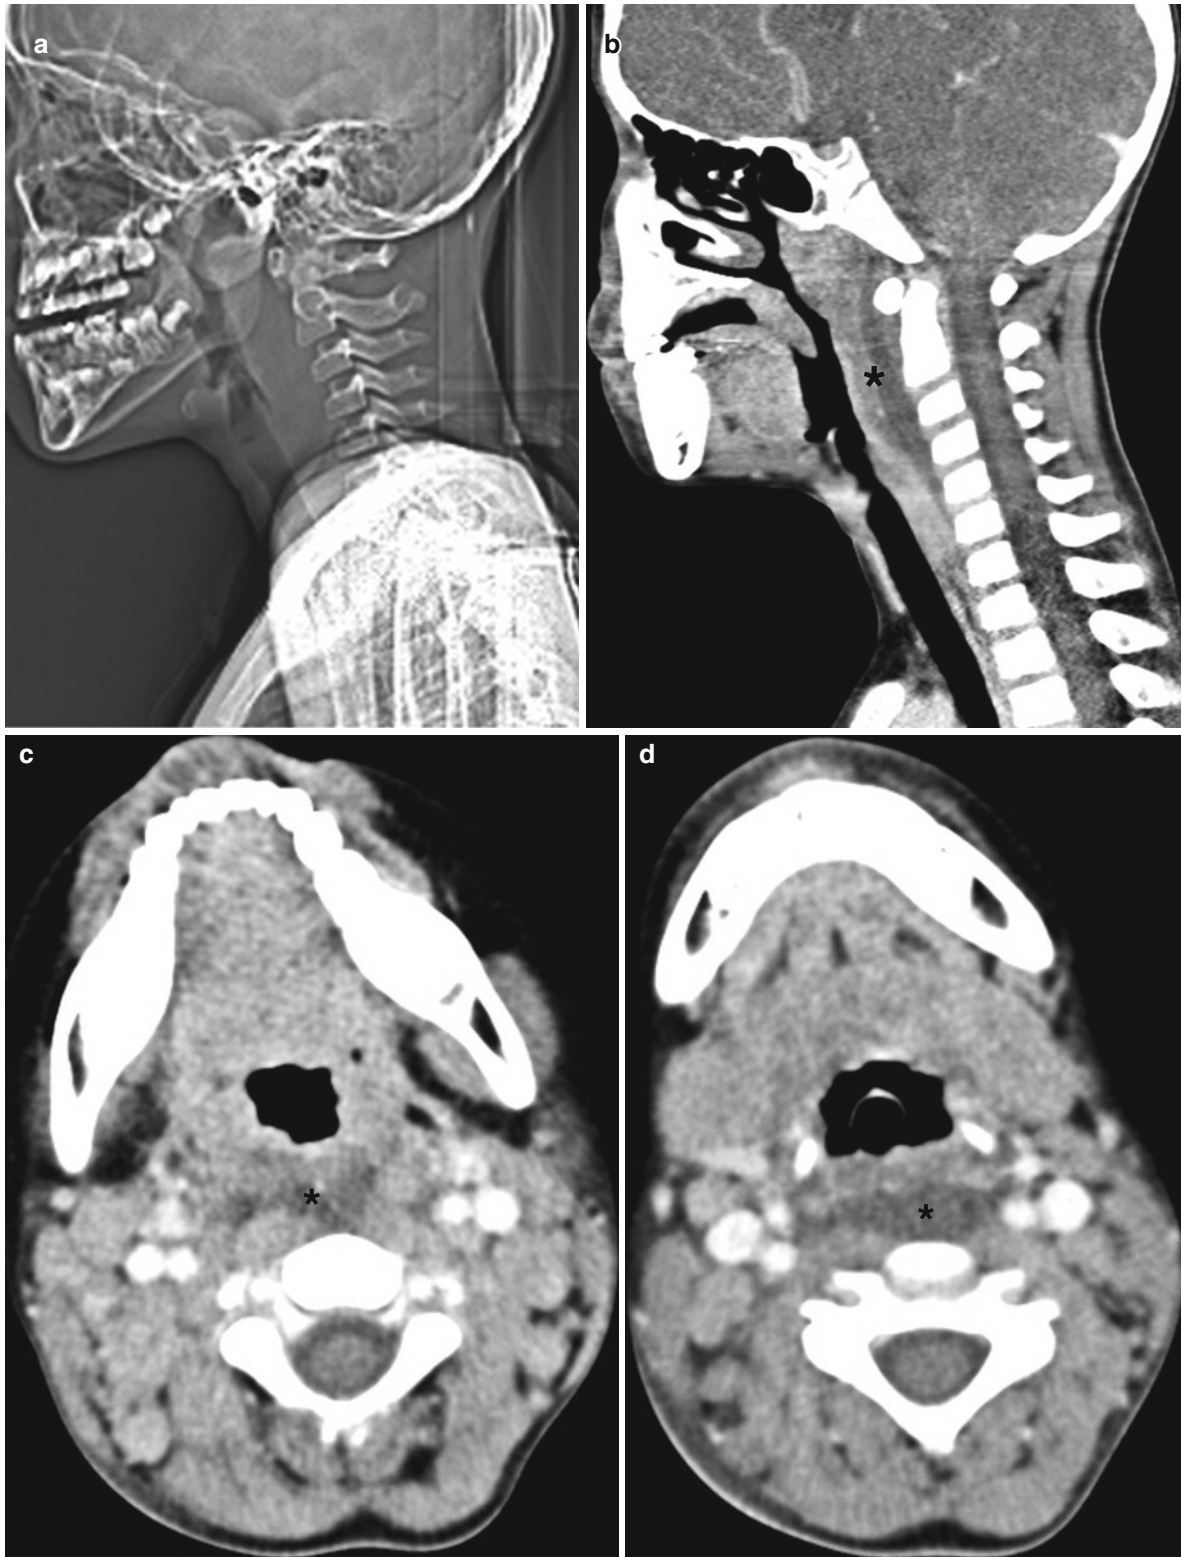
Mucocutaneous lymph node syndrome in a 5-year-old boy. He had a history of prolonged fever, cervical adenopathy, skin rashes, strawberry tongue, and conjunctival injection, which fulfilled the diagnostic criteria for Kawasaki disease. (a, b) CT scout image (a) and sagittal reconstructed image (b) show retropharyngeal soft tissue space
